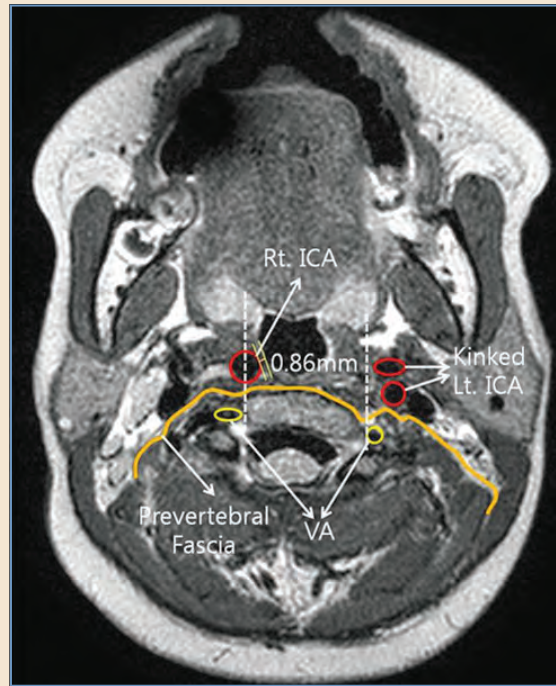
MRI showing a medially displaced right internal carotid artery (*Rt. ICA*). (*A*, Artery; *Lt. ICA*, left internal carotid artery; *V*, vein.)
